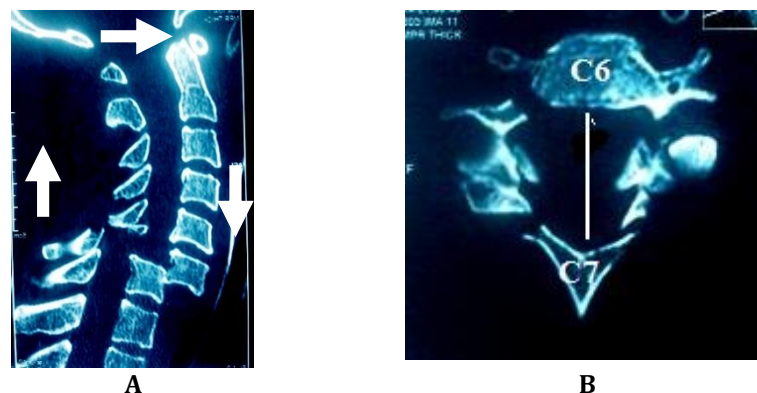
A CT scan showing dislocation of the vertebral body in the forward direction C6C7. The C6 body lies completely in front of the C7 body. The posterior arch and facet joints are broken, preventing compression of the spinal cord from the back. B. Cross-sectional CT scan across the dislocation. The spinal canal is enlarged, represented by the white line, the result of vertebral dislocation, complete fracture of the posterior elements.
